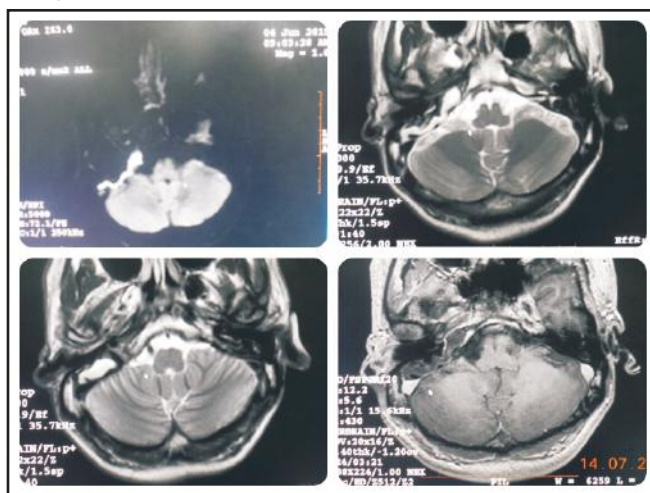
MRI showing mild restricted image on diffusion weighed image (1), hyperintense T2W images (2,3) and hypo to isointense T1W image(4)
